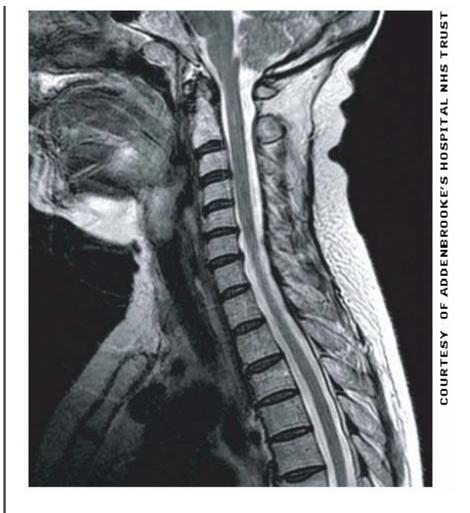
T2 weighted sagittal MRI of the cervical spine. There is impingement of the spinal cord at the C5/6 and C6/7 levels caused by degenerative disease. C2 (axis) is identifiable from the odontoid peg, that is embryologically derived from the body at C1 (atlas).
